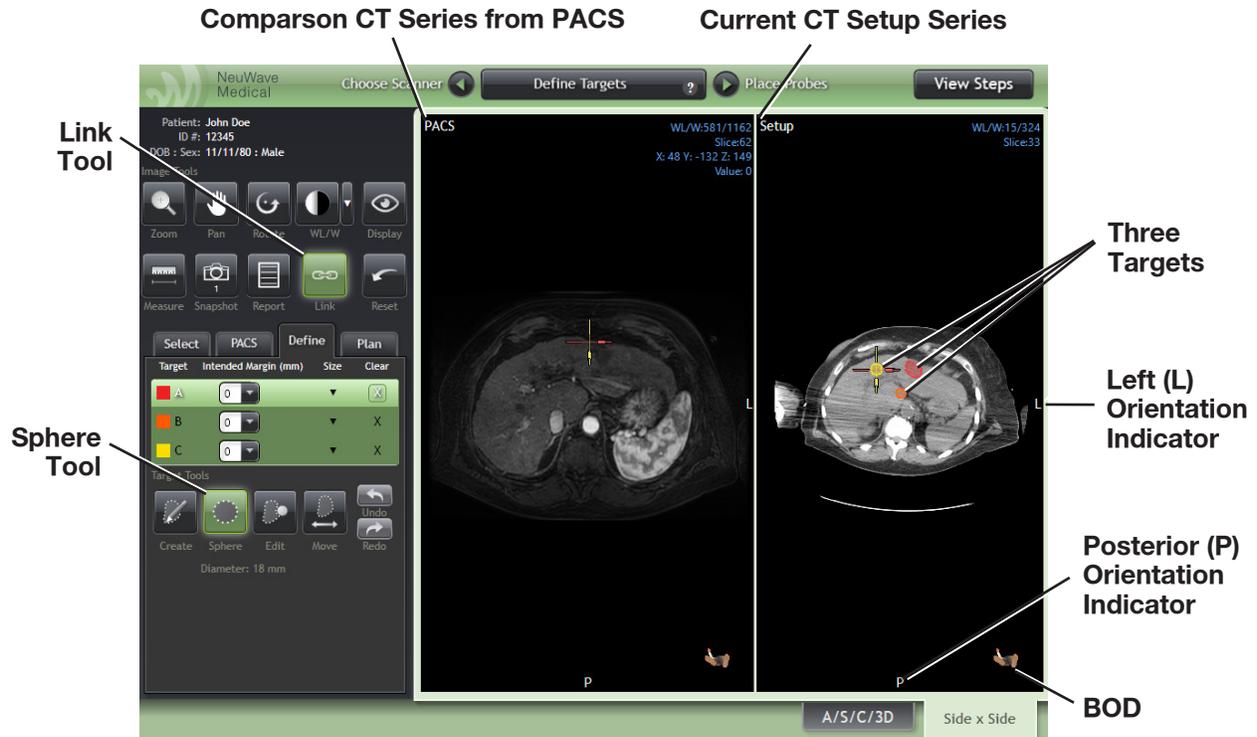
Side x Side Tab to compare the current Setup CT Series with a historical MR Series (Comparison MR Series) from the same patient. Three targets were created with the Sphere Tool as shown in the Target Selection Table.
